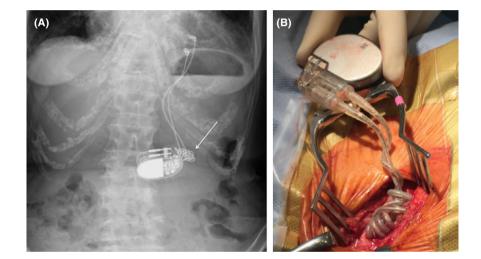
A, The chest radiographs showing numerous loops and twists of the pacemaker leads (White arrow). B, Intraoperative image showing the cluster of tangled leads connected to the device
